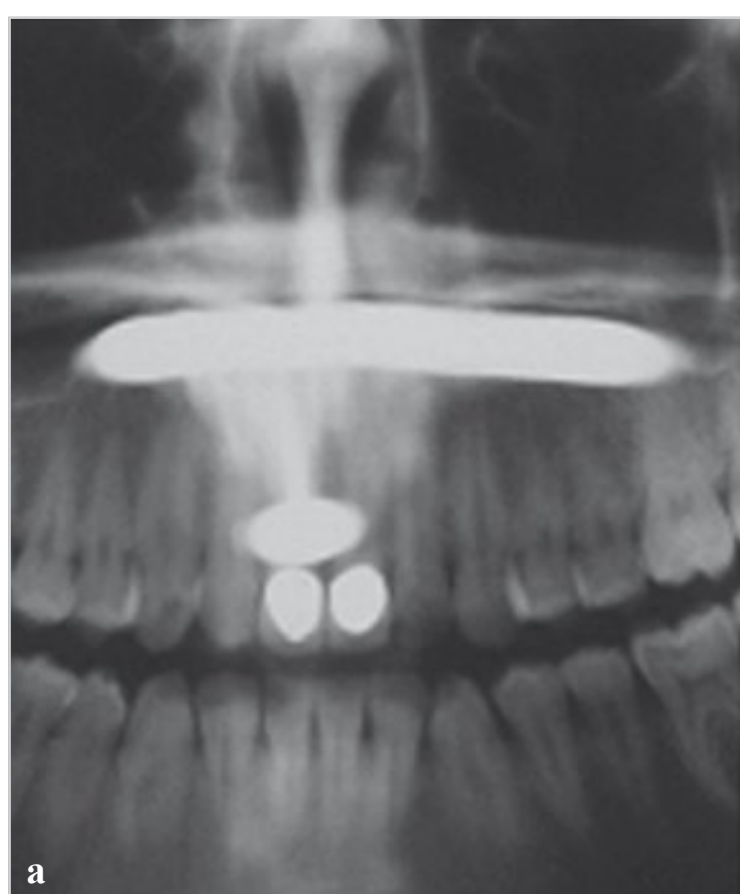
Effect of tongue piercing located in the rotation center of panoramic radiography.
